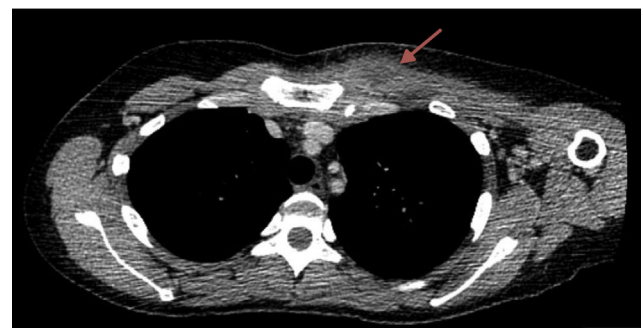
CT chest scan showing a 3 cm diameter lump at the level of the left pectoral muscle (arrow).
